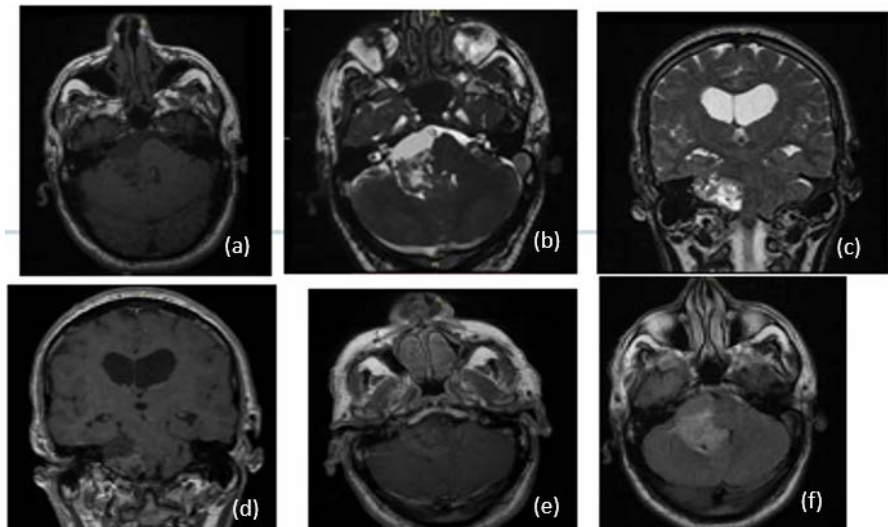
(a) Brain MRI shows an extra-axial process in the right ponto-cerebellar angle, hypointense on T1 (a) (d) (e), heterogeneously hyperintense on T2 (b) (c), enhancing moderately and heterogeneously, with cystic areas (f).
